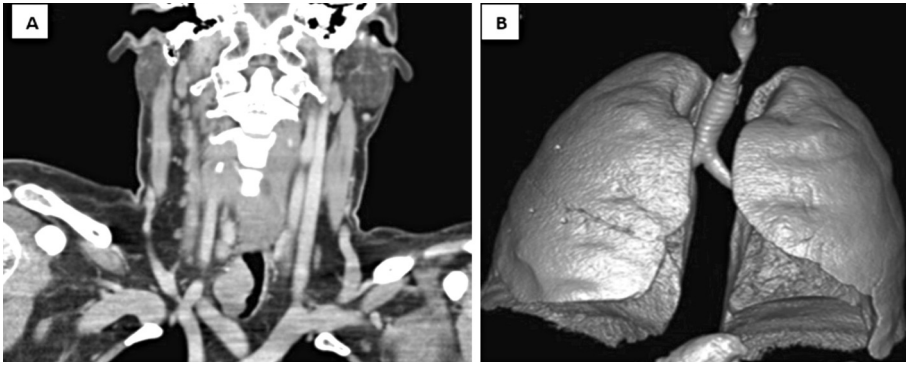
A) Computed tomography of the mass narrowing the lumen of the trachea; B) Virtual bronchoscopy image of the mass narrowing the lumen of the trachea.
